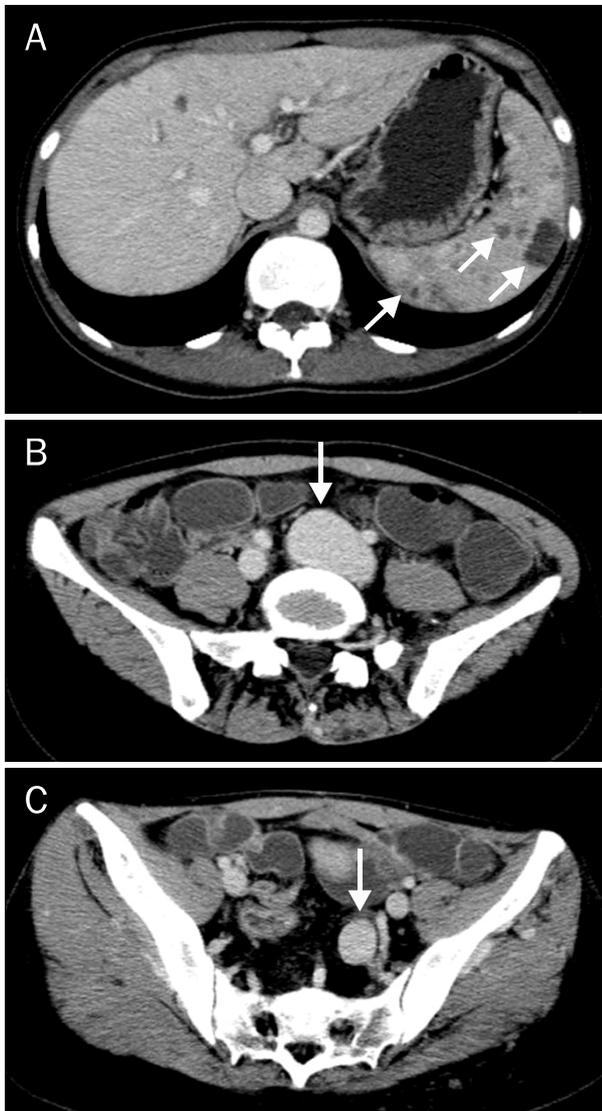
An abdominal CT scan revealed multiple hemangiomas in the spleen (A), and fusiform aneurysmal dilatation of the left common (B) and internal iliac veins (C).
